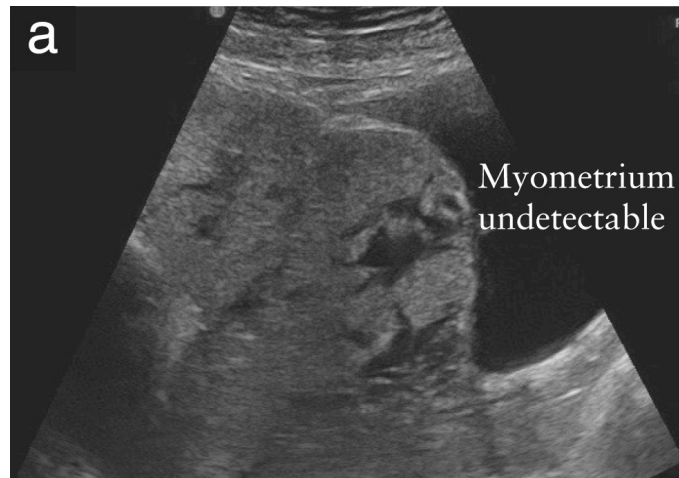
Transvaginal ultrasonogram at 32 weeks of gestation in a patient with placenta accreta spectrum. Note the complete loss of the retroplacental clear zone. The bladder serosa here appears hyperechoic and intact (arrow). In addition, the placenta is well visualized, with an absence of the myometrial border at the ureterovesical region (circled).
